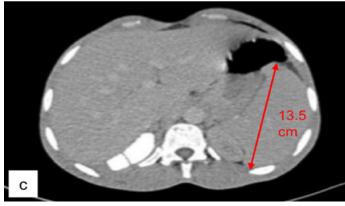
a) Computed tomography scan of the chest demonstrated multiple enlarged left axillary and subpectoral lymph nodes (outlined in red), some of which were necrotic measuring up to 3.6 cm. b) Computed tomography scan of the chest demonstrated a 1.6 cm right upper lobe pulmonary nodule (outlined in red). c) Computed tomography scan of the abdomen demonstrated mild splenomegaly, with a span of 13.5 cm.
